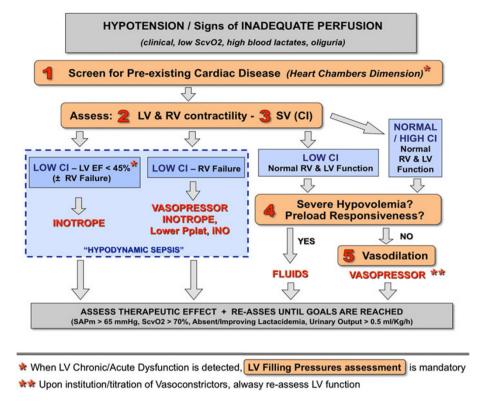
Septic Shock ECHO-based goal-directed algorithm. To monitor hemodynamics in septic shock the targets of the echocardiographic investigation are organized in a systematic five-step approach. Starting point is to detect potential signs of pre-existing chronic cardiac dysfunction (Step 1): LV or LA significant dilatation, and LV marked hypertrophy are signs or chronic volume/pressure overload; RA significant dilatation, RV dilatation and hypertrophy have the same meaning for right-side chronic disease (isolated RV dilatation can vice versa be a sign of acute RV dysfunction). If unrecognized, these findings can mislead in interpretation of subsequent findings (i.e. primary cardiogenic cause of shock, instead of sepsis; wrong assessment of volume status based on LV or RV dimensions). LV and RV systolic function must then be assessed (Step 2), together with cardiac output Doppler measurement (Step 3). A low output state can then be ascribed to sepsis-related LV systolic dysfunction (associated or not to RV dysfunction) or isolated RV dysfunction, and treated accordingly. Low output with evidence of normal biventricular
